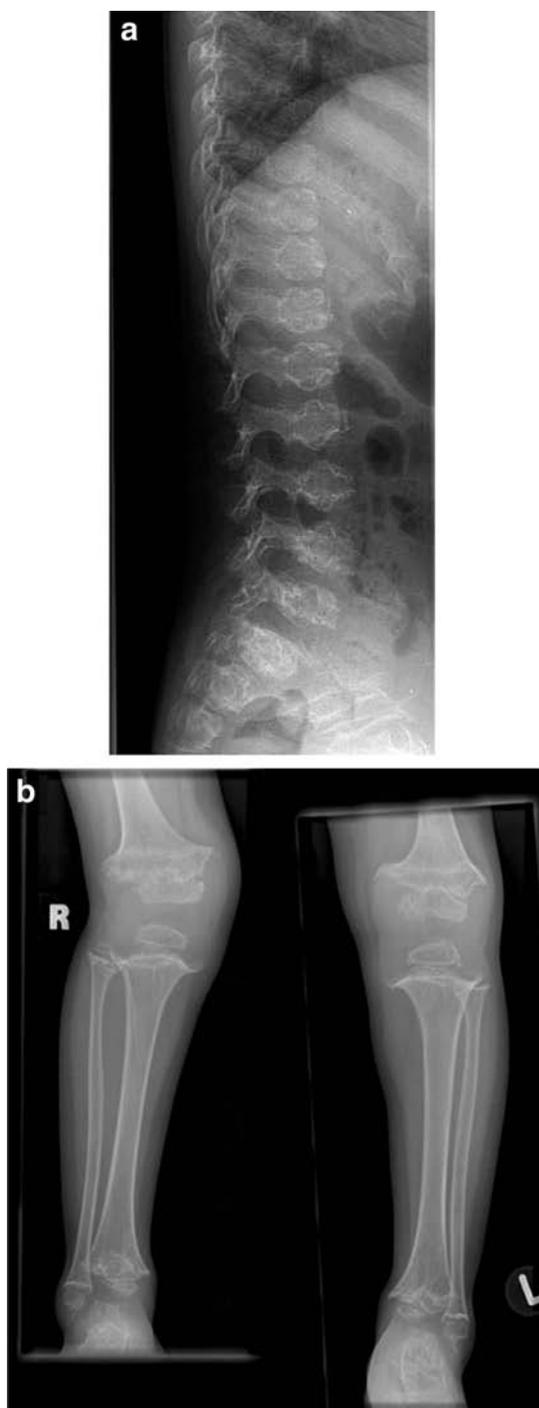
Radiographs of a 5-year-old girl with pseudoachondroplasia (PSACH). The lateral spine radiograph shows anterior beaking with central protrusion, which is typical of the disorder. At her knee, the epiphyses are small and dysplastic and the metaphyses are flared. In PSACH, the radiographic findings are sufficient and specific enough to allow for diagnosis.
